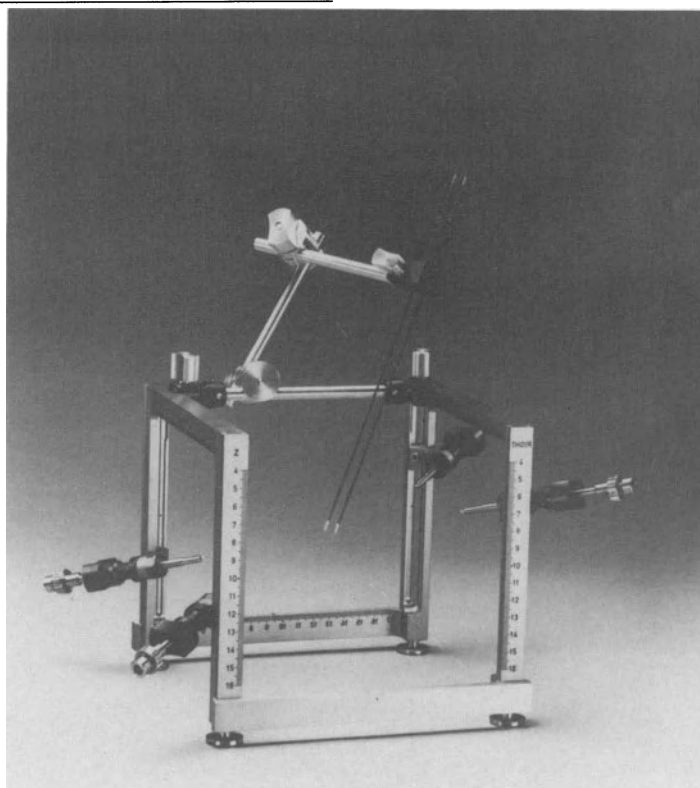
CT guide holder that replaces the semicircular arc for surgery performed under CT control.
